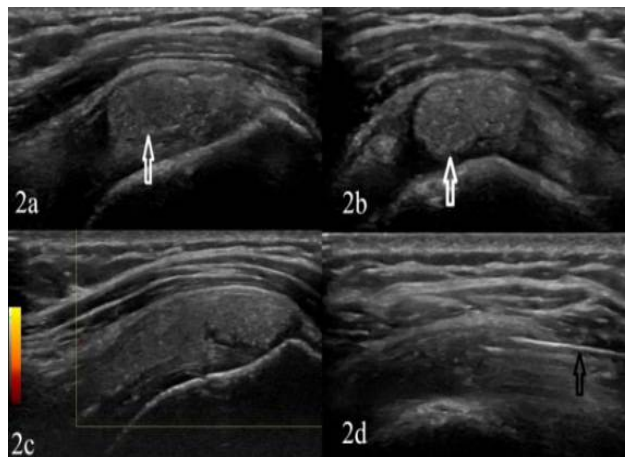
Ultrasound image of the supraspinatus tendon acquired in longitudinal and transverse view; 2a, 2b. Hyperechoic, inhomogeneous, well-defined area; 2c. Power Doppler ultrasound showing no vascularization; 2d. The puncture needle during intratendinous calcification aspiration (black arrow).
